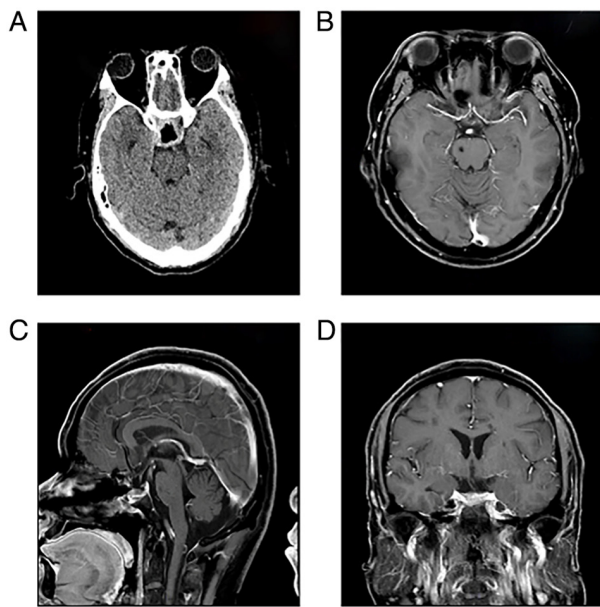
Postoperative imaging. (A) Postoperative computed tomography on postoperative day 3. (B-D) Postoperative gadolinium-enhanced magnetic resonance imaging at 6 months after surgery. (B) Transverse, (C) sagittal and (D) coronal images.
